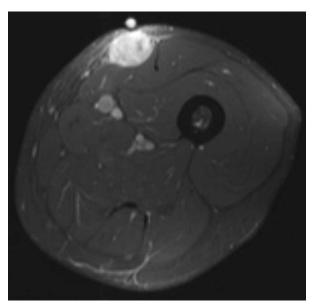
Axial T1-weighted fat-suppressed post-contrast image shows an enhancing mass in the anteromedial left thigh centered in the subcutaneous fat overlying the rectus femoris and sartorius muscles. Note the fiducial marker overlying the mass.
